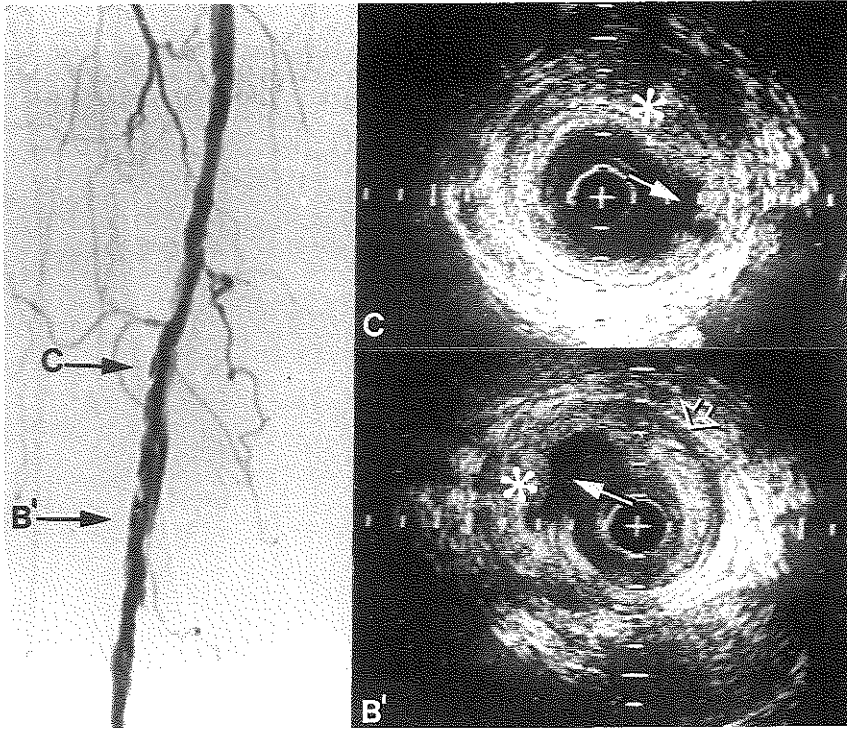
Angiogram and intravascular ultrasound images obtained following balloon dilatation. The angiogram reveals a larger lumen and an irregular surface suggesting intimal tears. Corresponding ultrasound images (B' and C) are from the level that was previously occluded and dilated. The lumen is significantly increased (80%). Substantial residual atherosclerotic lesion is still present (asterisk). The ruptured plaque (arrows) and dissection (open arrow) became apparent only after saline injection. The dark layer corresponding with the thinned media is seen between 5 and 8 o'clock in C. Calibration markers are 1 mm.
